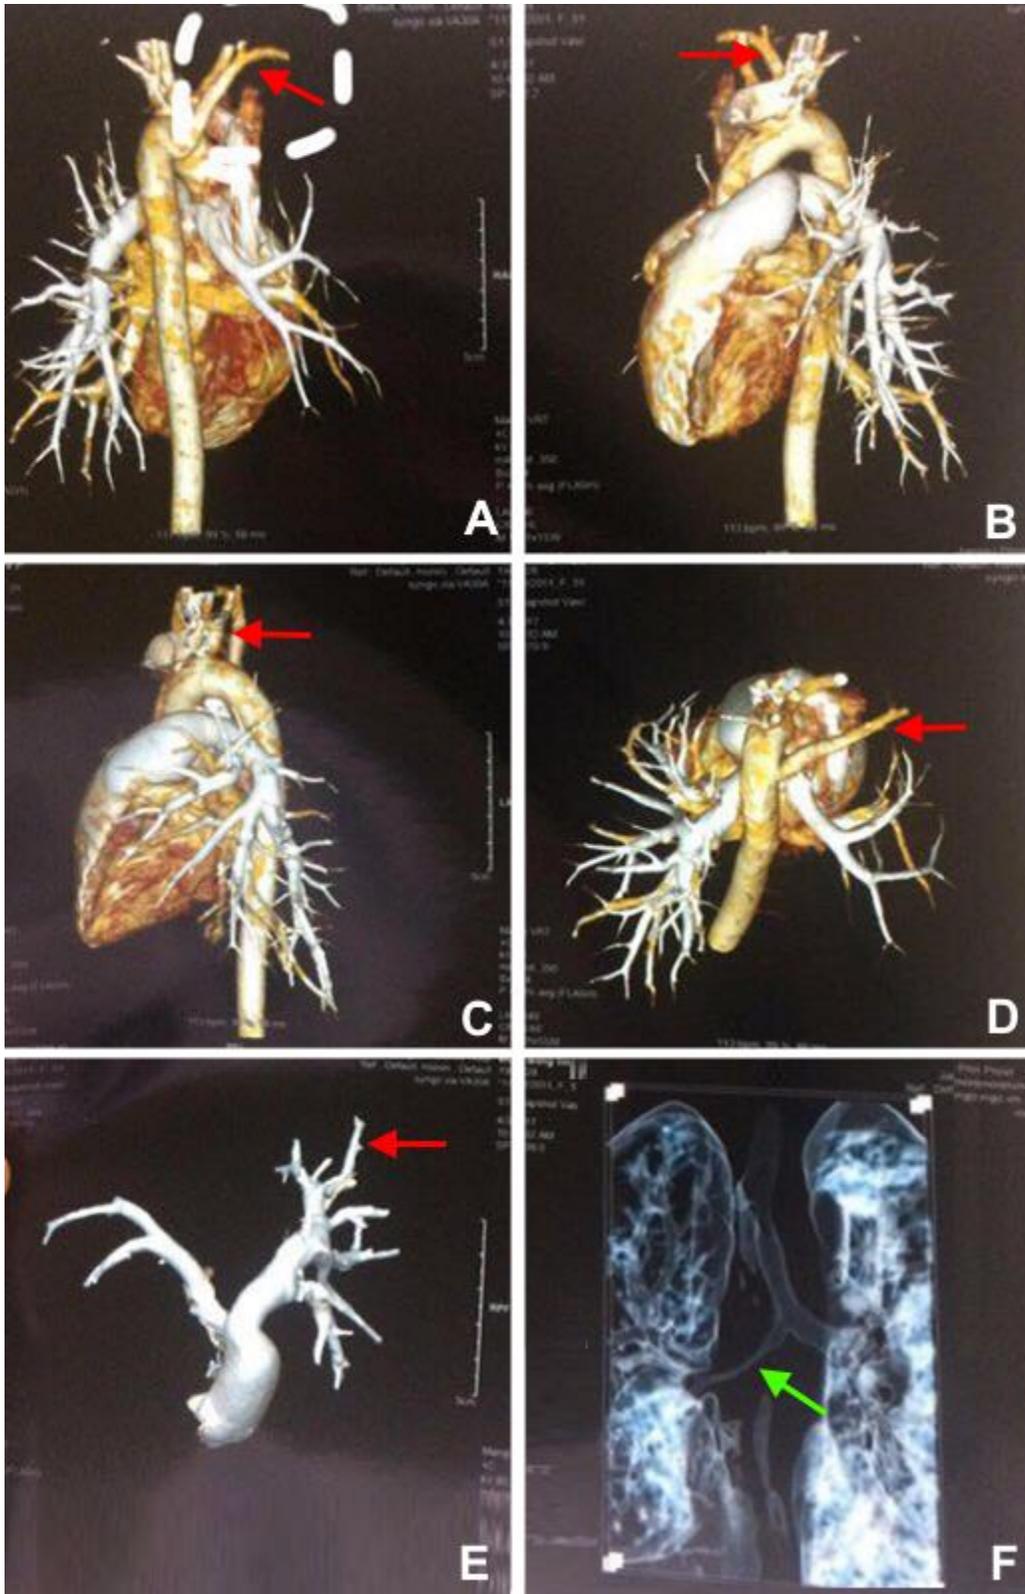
CT Angiography results of the aberrant right subclavian artery and narrowed right bronchial lumen. A-E = Aberrant right subclavian artery (red arrows); F = narrowed right bronchial lumen (green arrow).
